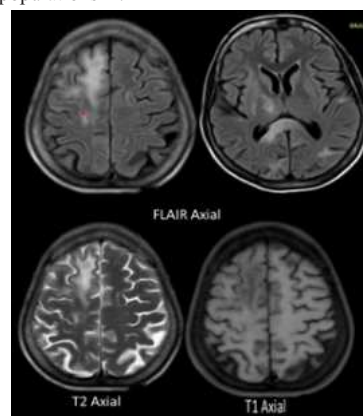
Case of a 41-year-old male patient with Progressive Multifocal Leukoencephalopathy (RVD positive), MRI shows bilateral asymmetrical multifocal and confluent areas of T1 hypointensity and T2/FLAIR hyperintensities in the subcortical white matter of the bilateral cerebral hemispheres. There is also involvement of the subcortical U-fibers and the corpus callosum.
